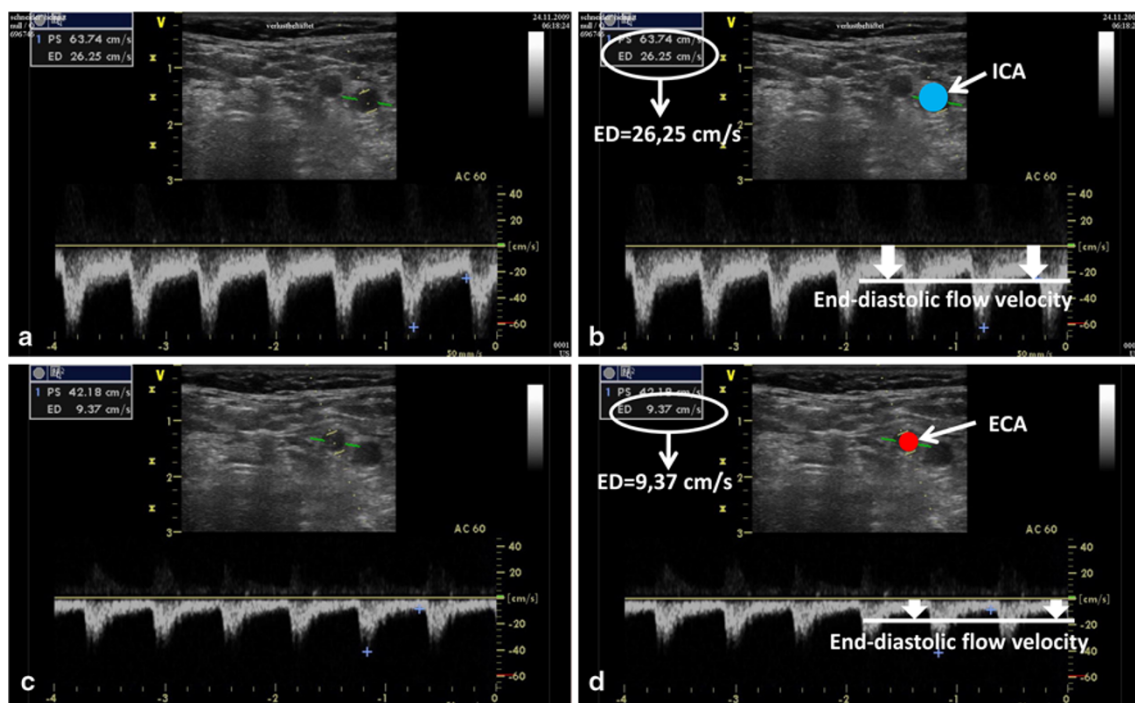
Example of duplex sonography of a patient with cardiomyopathy. Extracranial internal carotid artery (ICA), external carotid artery (ECA). Flow signals below B-Mode images; b, d end-diastolic flow velocity (ED) marked with an arrow, value (cm/s)
